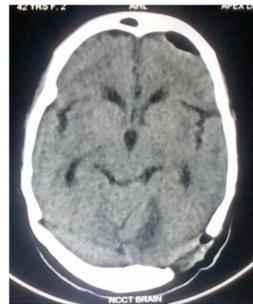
Pre op and post op CT of sphenoid wing meningioma
